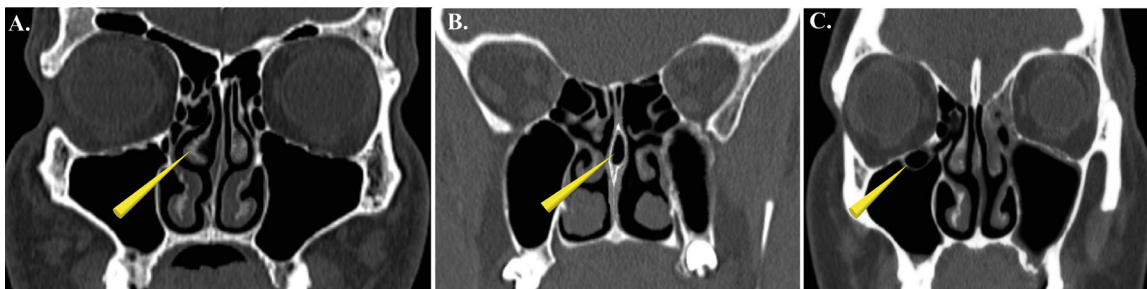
Computed tomography. (A) The hook-shaped middle nasal turbinate on the right side and (B) the septa bullosa. The nasal septum contains an air cell in the posterior 1/3 of its length. (C) The right maxillary sinus contains a Haller cell located near the lower-medial orbital wall.
